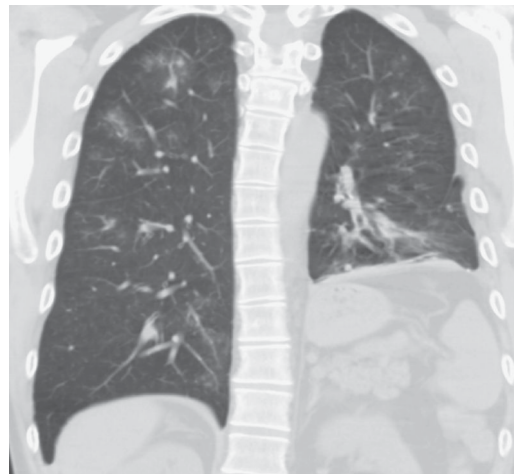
CT chest (coronal view) revealing patchy areas of ground glass opacification, right > left with elevation of the left hemidiaphragm.
